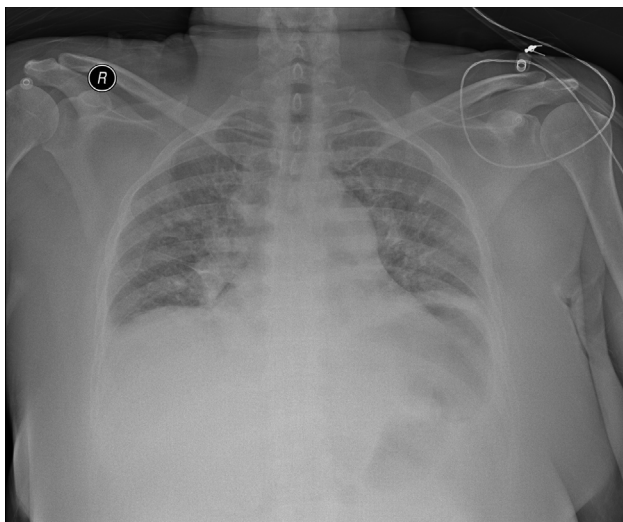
Anteroposterior Chest X-ray with elevated left hemidiaphragm and turgescient vascular hili.
